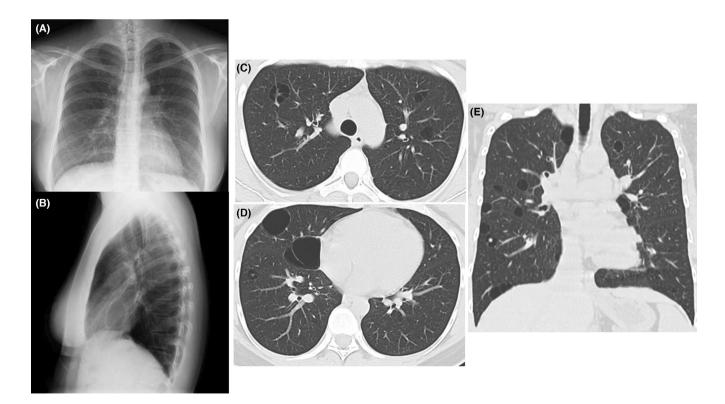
Radiological examination. The frontal chest X-ray (A) is normal, but in the lateral projection (B), a cyst-like shadow is observed superimposed on the heart shadow. Computed tomography (C–E) demonstrates multiple, bilateral, and thin-walled cysts that are distributed throughout the pulmonary parenchyma. Vessels can be seen within some cysts (C, D). There are no other findings, including centrilobular nodules, bronchial wall thickening, interstitial changes, or lymphadenopathy.
